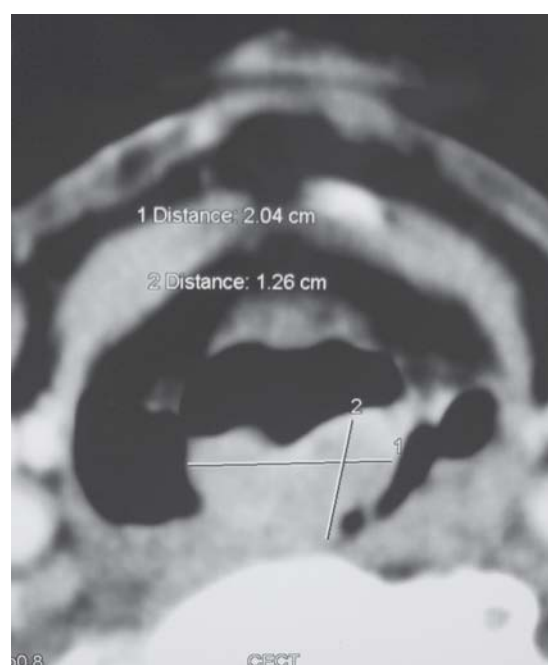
CT scan of the larynx showing the tumor
